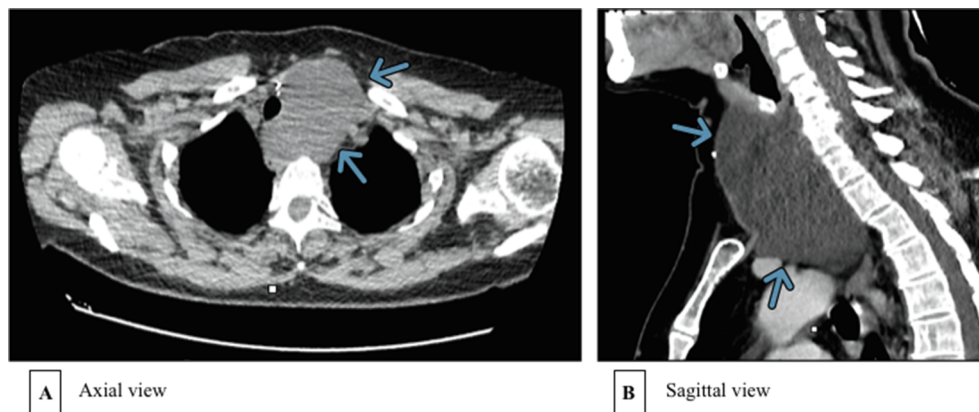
(A) Axial section of contrast-enhanced CT showed a large mass (77x52x107 mm)(arrow) located in the left thyroid loggia, with well-defined margins, right deviation of the trachea and infiltration of the antero-superior mediastinum. (B) Sagittal section of contrast-enhanced CT.
